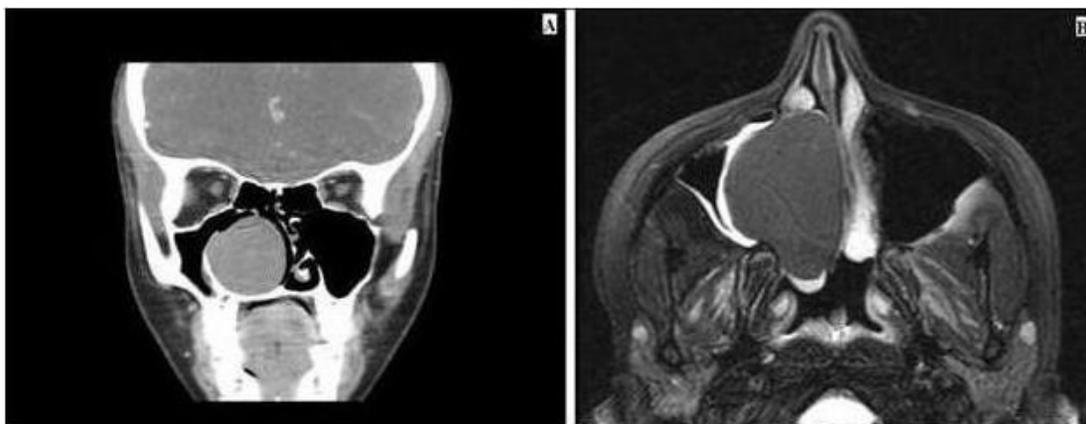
a) Coronal CT image shows a right sided nasal cavity mass caused obstruction and expansion of the right nasal cavity. b) Axial MRI image shows a homogeneous right nasal cavity mass extended to the postnasal space.
